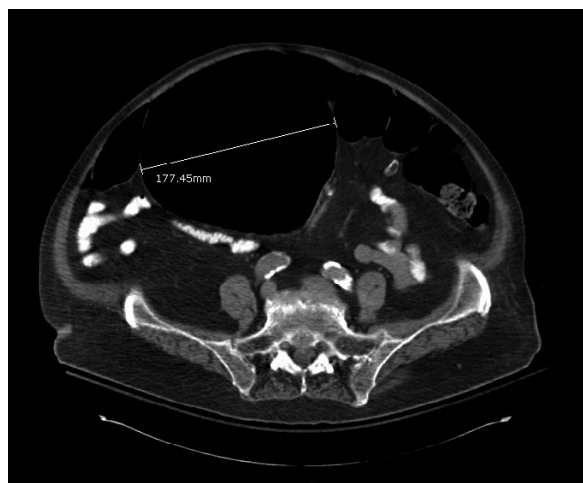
Abdominal computed tomography with contrast showing marked dilation of the sigmoid colon measuring up to 17 cm in diameter containing air-fluid level, fecal debris, and lack of retro-peritoneal bleeding
